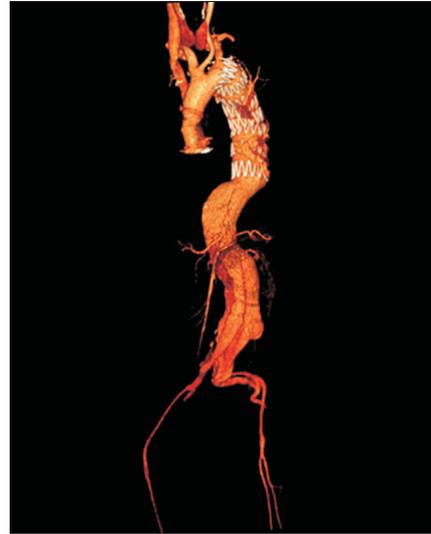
Follow-up computed tomography angiography three dimensional reconstruction of the aorta from 2012, revealed the chronic dissection and extensive aneurysmal degeneration of the thoracoabdominal aorta (measuring 6.4 cm) extending to both common iliac arteries (measuring 2.3 cm in the right and 2.9 in the left).
